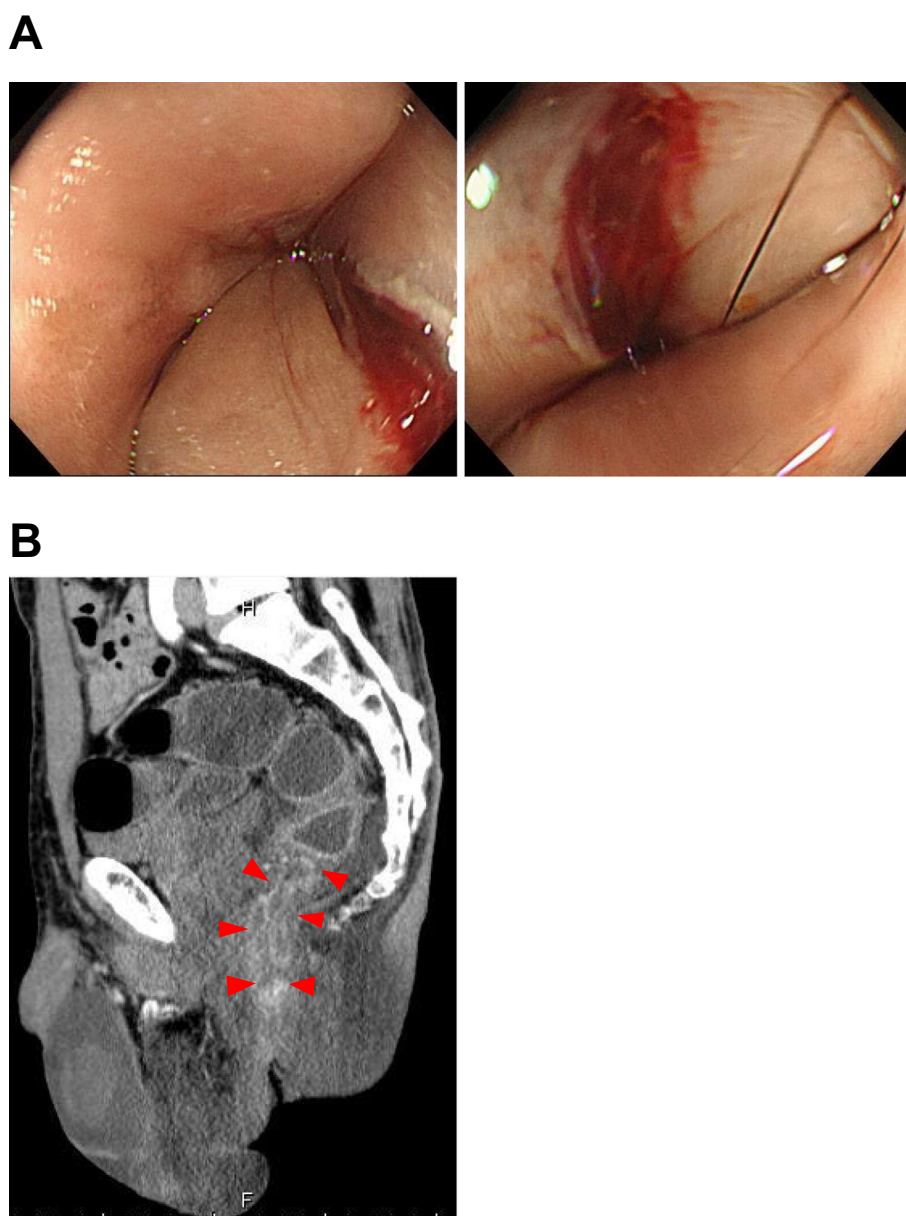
Colonoscopy and computed tomography (CT). (A) Colonoscopy revealed two lacerations in the edematous mucosa below the anal dentate line. (B) Abdominal CT revealed that contrast effect (arrowheads) was limited within the mucosal lesion.
